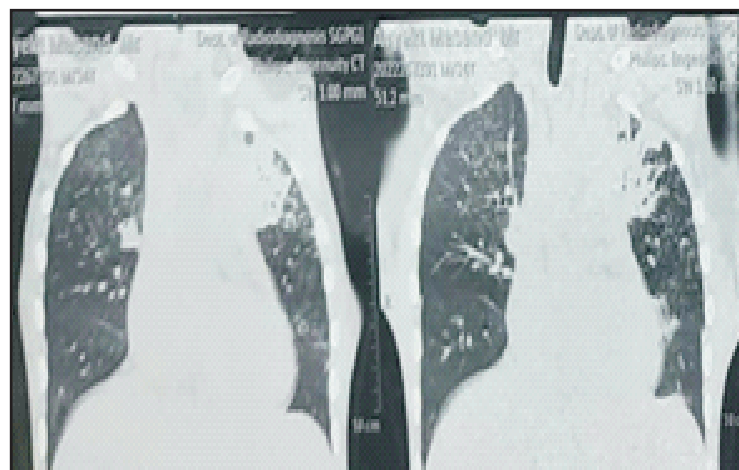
CT scan of chest showing patchy area of consolidation on left upper lobe (yellow arrow) with multiple centrilobular nodule in both lungs as tree in budding appearance (red arrow)
